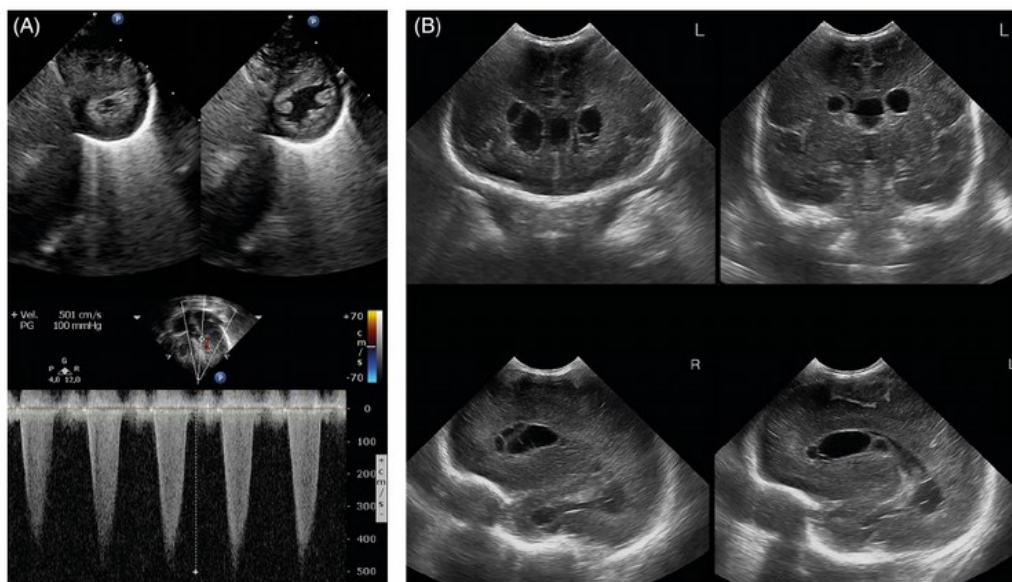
Sonographic findings in patient 9. “(A) Echocardiography showing hypertrophic interventricular septum with left-ventricular noncompaction pattern (left, systole; right, diastole) and left ventricular output tract pressure gradient (PG). (B) Cerebral ultrasound showing multiple periventricular cysts, hyperechoic periventricular white matter and poor gyration. Top line: coronal views; bottom line: sagittal views. L: left, R: right. Picture and legend taken from [17].”
